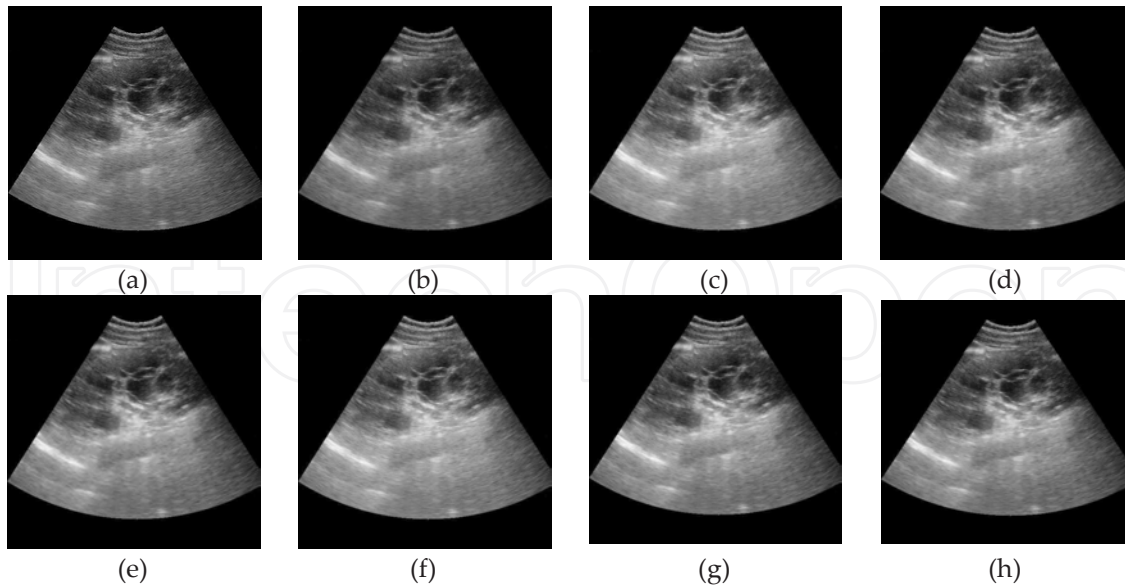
a) Original ultrasound image, (b) Denoised image using Gaussian filter, (c) Denoised image using 1st alternative with WT method (d) Denoised image using 1st alternative with LP method. (e) Denoised image using 1st alternative with CT method. (f) Denoised image using 2nd alternative with WT method. (g) Denoised image using 2nd alternative with LP method. (h) Denoised image using 2nd alternative with CT method.
